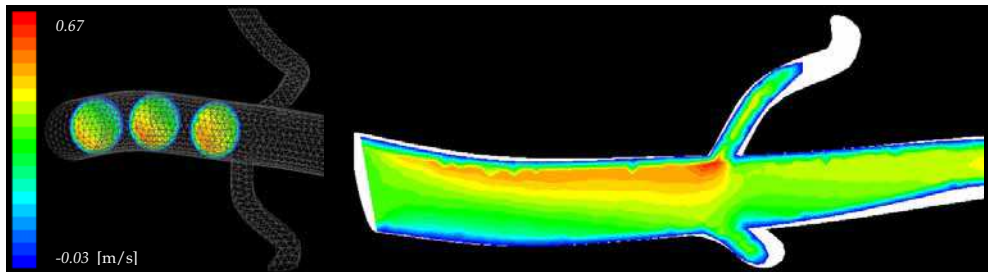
Velocity profiles for the model obtained from CT images
